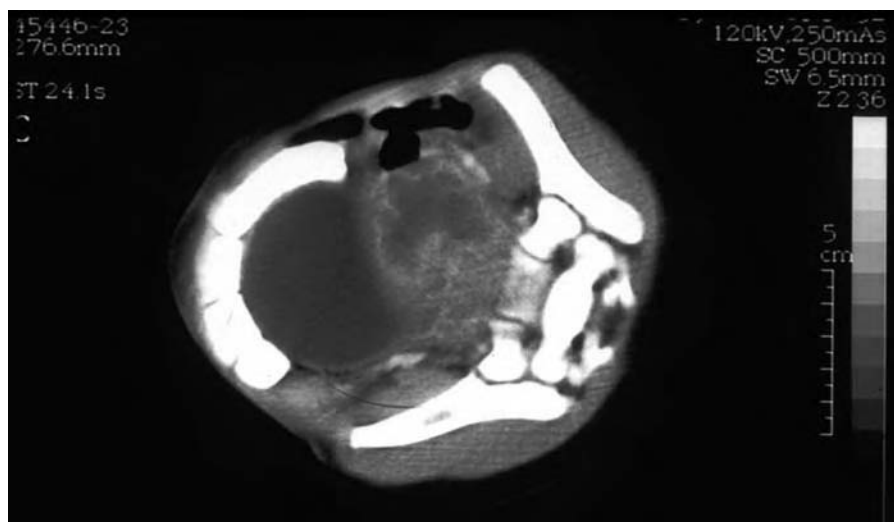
CT scan showing a large pelvic abscess resulting from a perforated appendix.
